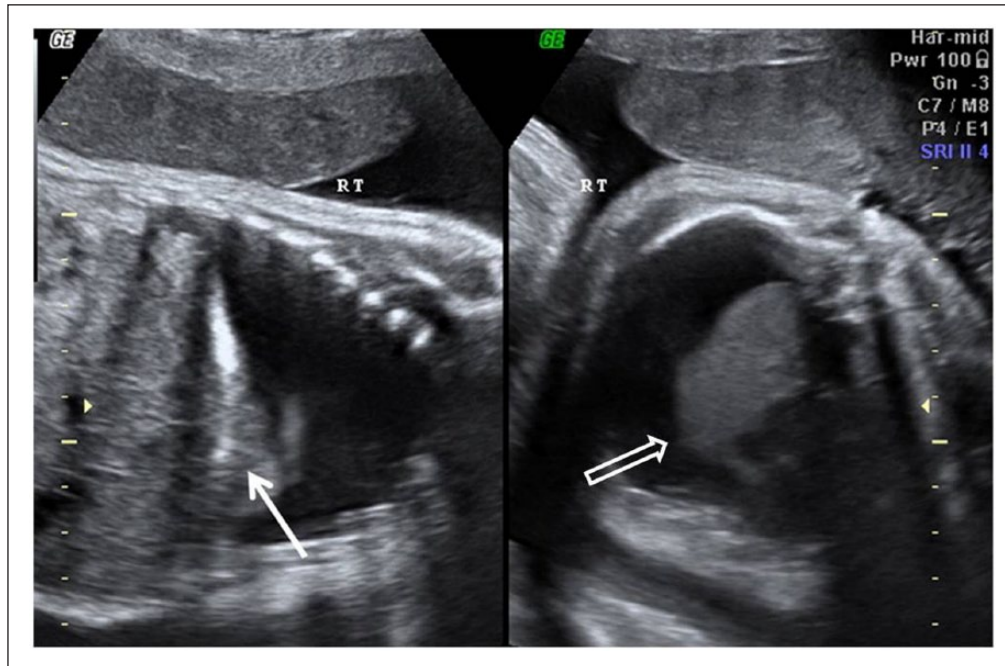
Prenatal ultrasound at 34.5 weeks of gestation age shows a large right hydrothorax, reaching 77mm × 49mm × 29mm with the right lung being compressed (open arrow), and the hyperechogenic mass (closed arrow) is recognized in the retrospection of the images.
